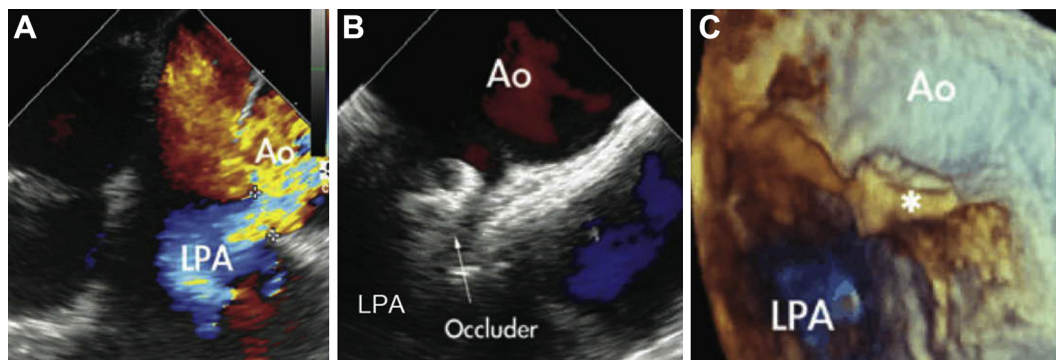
(A) Two-dimensional (2D) transesophageal echocardiography (TEE) showed a large patent ductus arteriosus (PDA) (12-mm width) of the “window-like” type. Color Doppler flow image documented continuous left-to-right shunting from the aorta (Ao) into the left pulmonary artery (LPA); (B) transcatheter closure of PDA with the Amplatzer duct occluder (Occluder) in optimal position; and (C) real-time 3D TEE documenting the occluder (*) inside the PDA from the aortic perspective.
